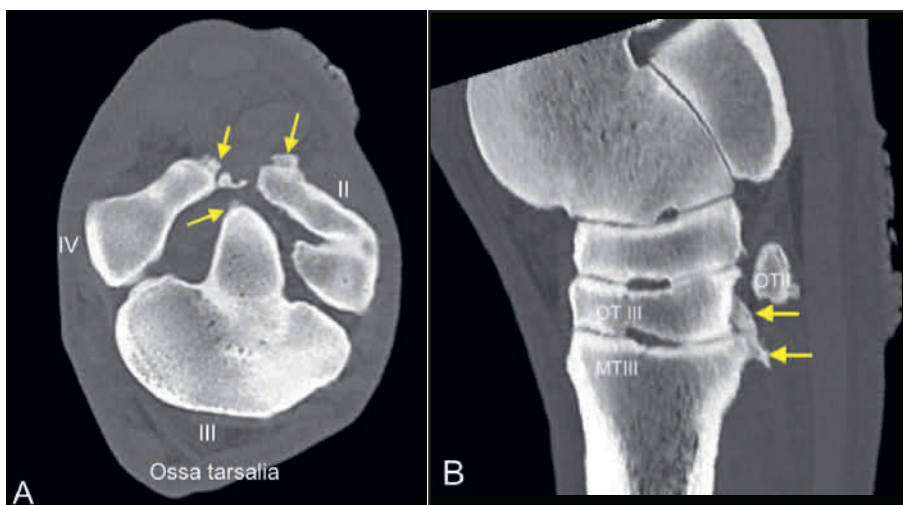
Transverse (A) and sagittal (B) reformatted CT images of the right tarsus on the level of the distal tarsal bones (A) respectively in a medial paramedian plane (B) in bone algorithm. Yellow arrows indicate new bone formation at 2nd, 3rd and 4th tarsal bone (A, B) and bridging new bone formation between 3rd tarsal (OTIII) and 3rd metatarsal bone (MTIII; B). | Transversale (A) und sagittale (B) reformatierte CT-Bilder des rechten Tarsus auf Höhe der distalen Tarsalknochenreihe (A) bzw. in einer leicht medial gelegenen paramedianen Ebene (B) im Knochenalgorithmus. Gelbe Pfeile markieren knöcherne Zubildungen an den Ossa tarsalia II, III und IV (A) und überbrückende Zubildungen zwischen Os tarsale III (OTIII) und Os metatarsale III (MTIII; B).
